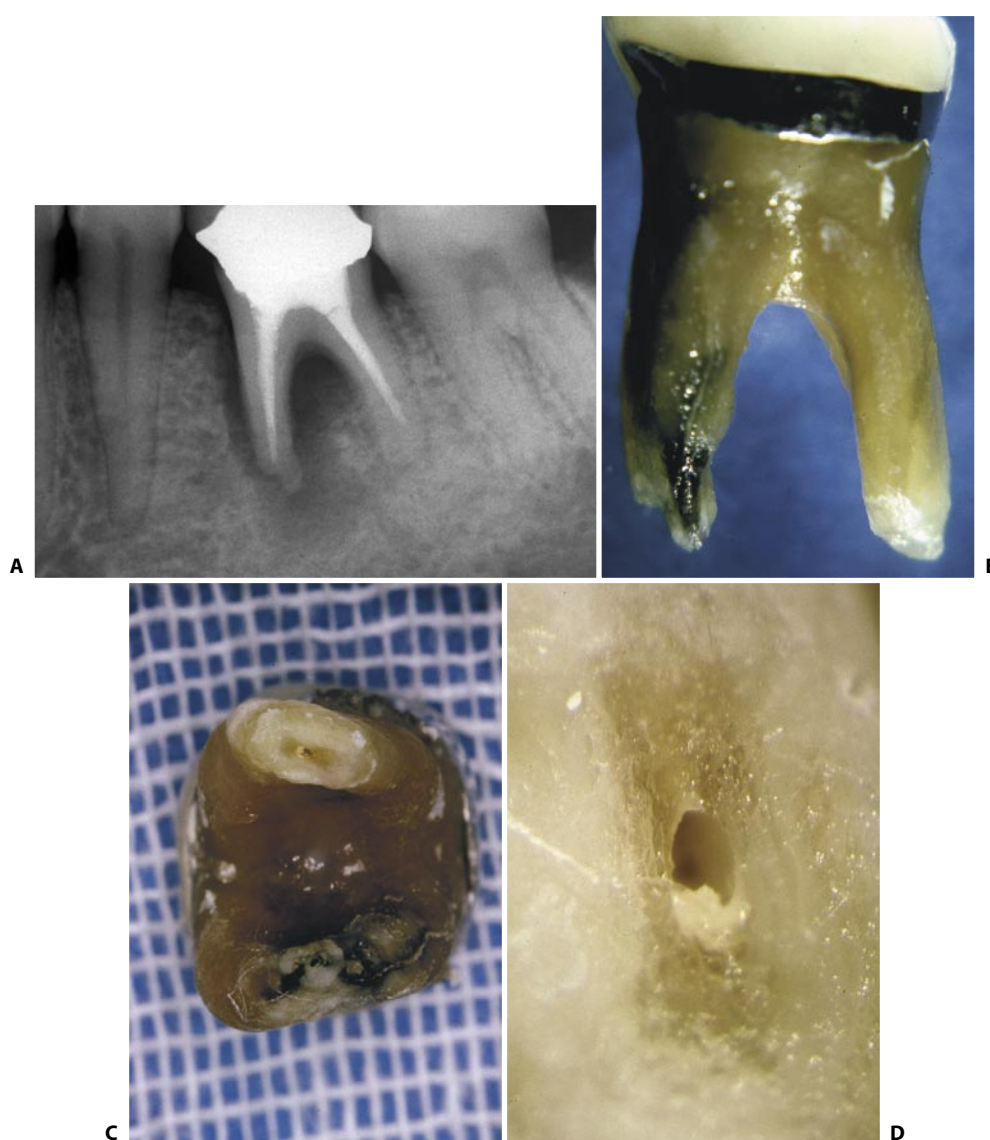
A. The first lower molar of this patient has been treated endodontically with the lateral condensation technique, staying short of the radiographic apex, to let the “biologic” closure of the apical foramen happen by the “great actors of apical healing”. The tooth has a vertical root fracture of the mesial root and therefore has to be extracted. B. The vertical root fracture is evident on the extracted tooth. C. The photograph is showing the apical foramina of the two roots. D. The foramen of the distal root at higher magnification: the foramen is still wide open and the unfilled portion of the root canal can act as a reservoir of bacteria and obviously cause an endodontic failure!
